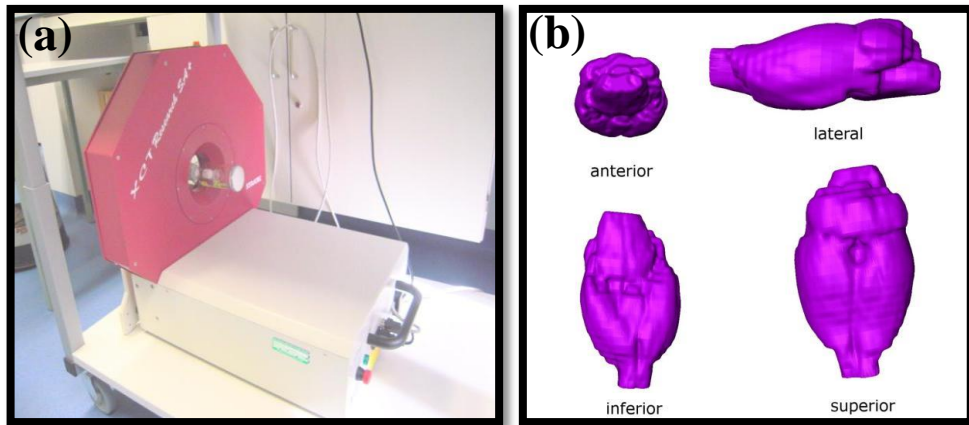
(a) Peripheral quantitative computed tomography (pQCT) Stratec Research SA+ scanner (Stratec Medizintechnik, Pforzheim, Germany) and (b) images obtained from it.
